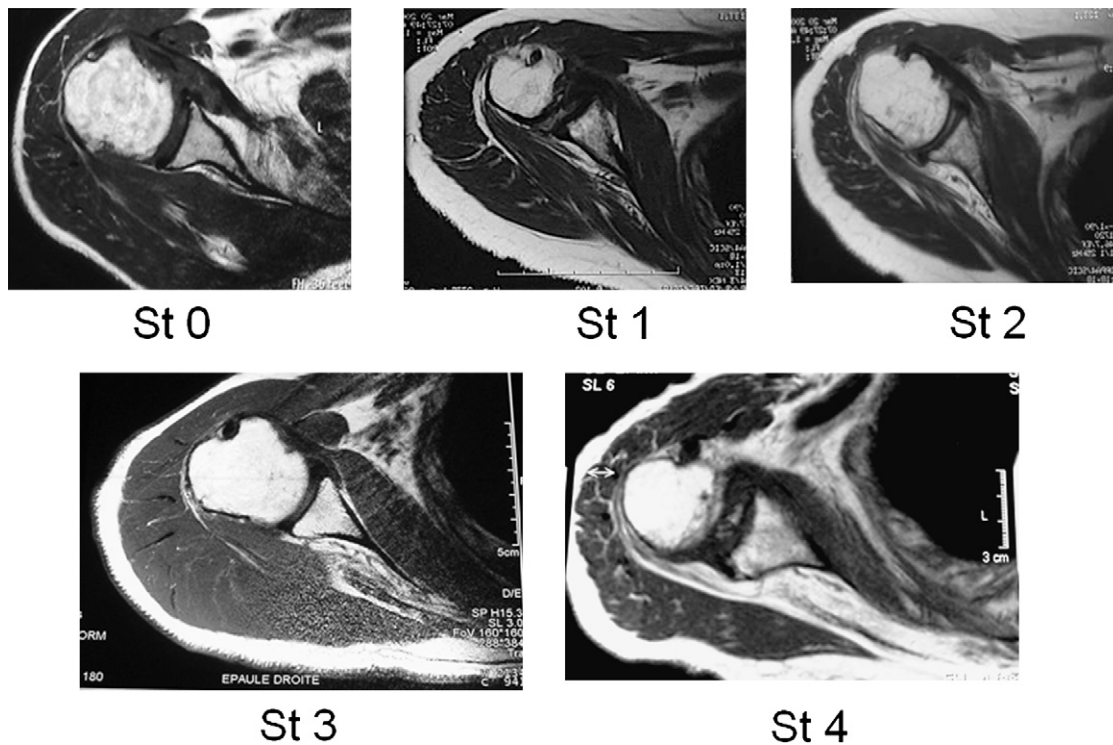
Infraspinatus fatty infiltration grading according to Goutallier and Bernageau classification applied to MRI.
